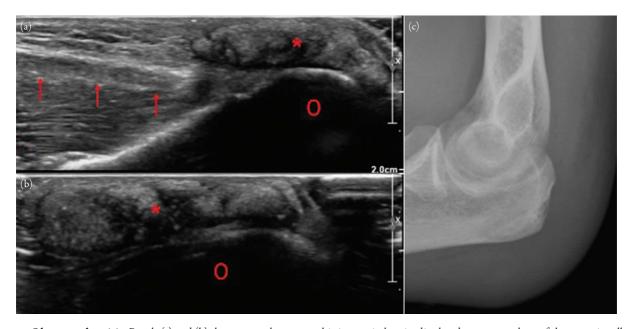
Olecranon bursitis. Panels (a) and (b) show grayscale sonographic images in longitudinal and transverse plane of the posterior elbow with a lobulated subcutaneous soft tissue mass in the region of the olecranon bursa. The mass (*) is located posterior to the distal triceps tendon (arrows) and posterior to the olecranon (O). Elbow radiographs (Panel (c)) show posterior elbow soft tissue swelling with a small posterior olecranon bone erosion.
